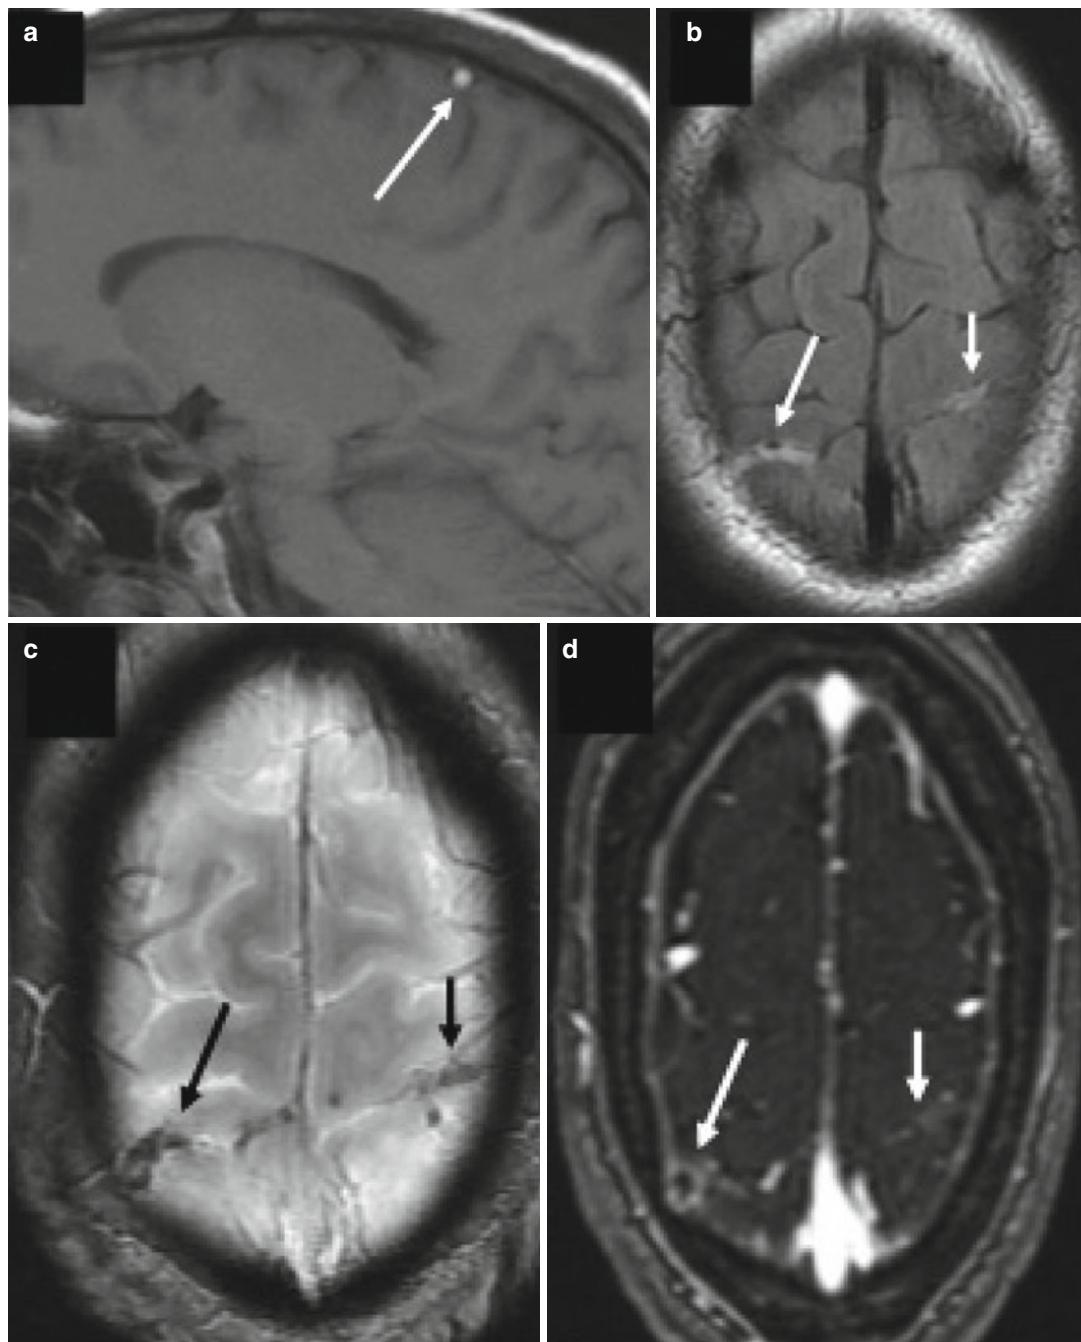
Cortical thrombosis in a patient treated with asparaginase for acute lymphoblastic leukemia. (a) Sagittal T1: hyper T1 thrombus in a cortical vein (arrow). (b) Axial FLAIR: hyperintense cortical veins (arrows) without associated parenchymal abnormality. (c) Axial
